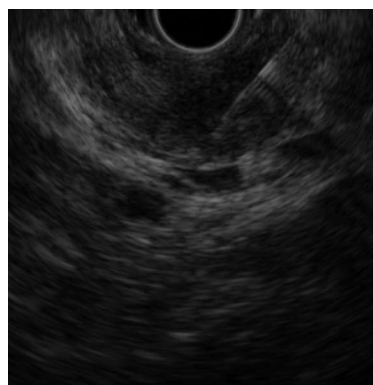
Endoscopic ultrasonography-guided fine needle aspiration of the 20-mm hypoechoic mass lesion was performed using a 22-G needle.
